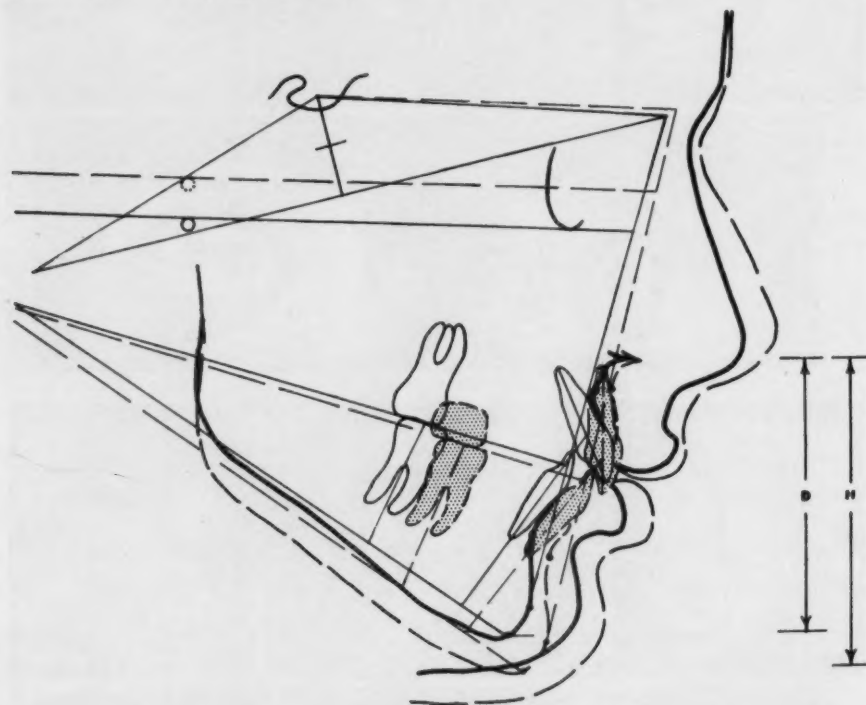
Case 6, Patient E. R. Superposed tracings of cephalometric roentgenograms. Solid line, September, 1951; broken line, May, 1955.
